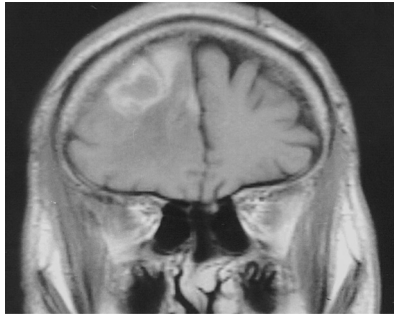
Magnetic resonance imaging (MRI) scan (post-contrast T1-weighted image) demonstrating a focal mass-like lesion with ring enhancement within the right frontoparietal area in a 30-year-old HIV-positive patient whose presenting symptoms included mental status changes. The primary differential diagnosis is between lymphoma and toxoplasmosis. (From Goetz C. *Textbook of clinical neurology*. 3rd ed. Philadelphia: Saunders, 2007, Fig. 23-34.)
